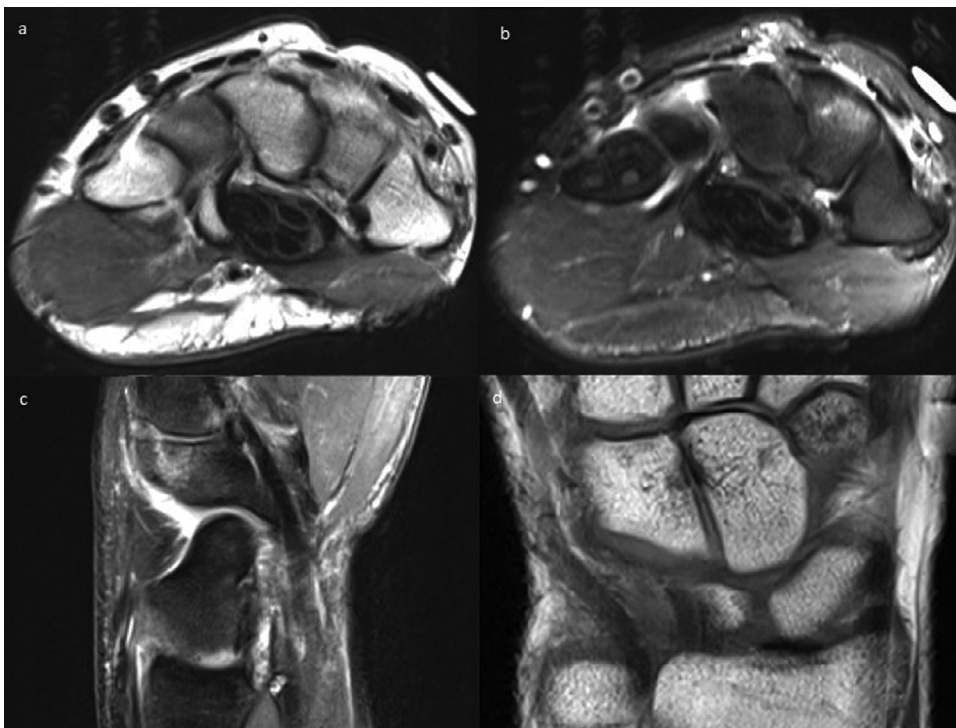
Axial proton density image (a) demonstrates another coronally-oriented band of low signal with corresponding edema on T2, fat-saturated images in both axial (b) and sagittal planes (c), similar to [Figure 2](#). There is a vitamin E marker in the area of the referred pain and the study is somewhat limited by motion. The fracture is difficult to see on coronal T1-weighted images, and there is no additional evidence of fracture (d).
